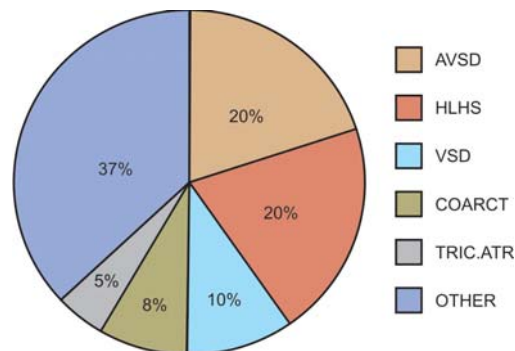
Incidence of CHD detected by fetal echocardiography³⁹
